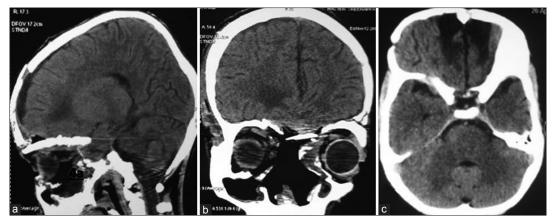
Postop CT scan (a) sagittal and (b) coronal sections showing no significant residual tumor. (c) Axial sections at the level of greater wing of sphenoid showing minimal edema of the bilateral basifrontal regions
